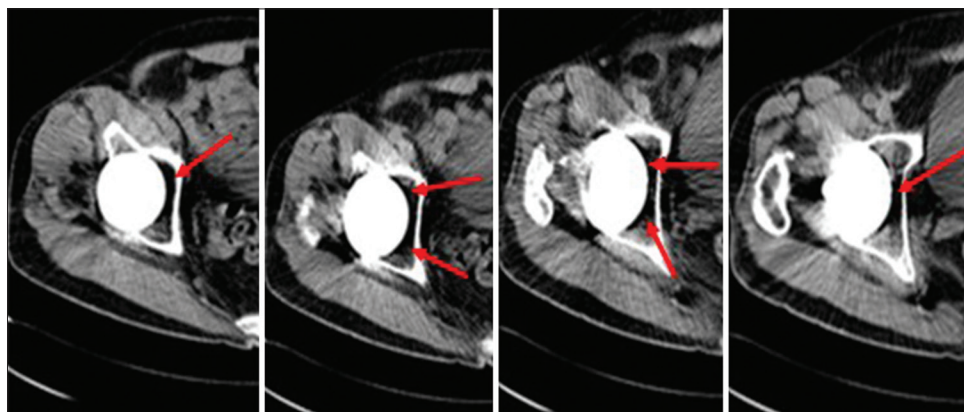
Computed tomographic scan of the right hip 12-year after surgery, revealing local osteolysis around the acetabular component
